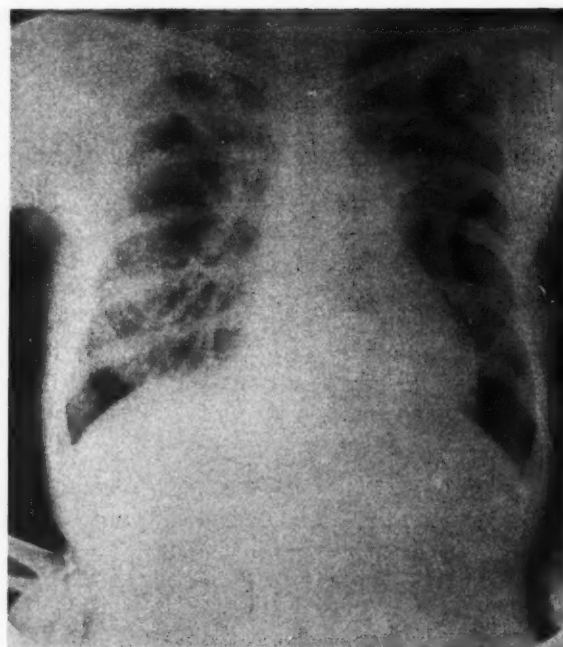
Chest roentgenogram October 6, 1947.
